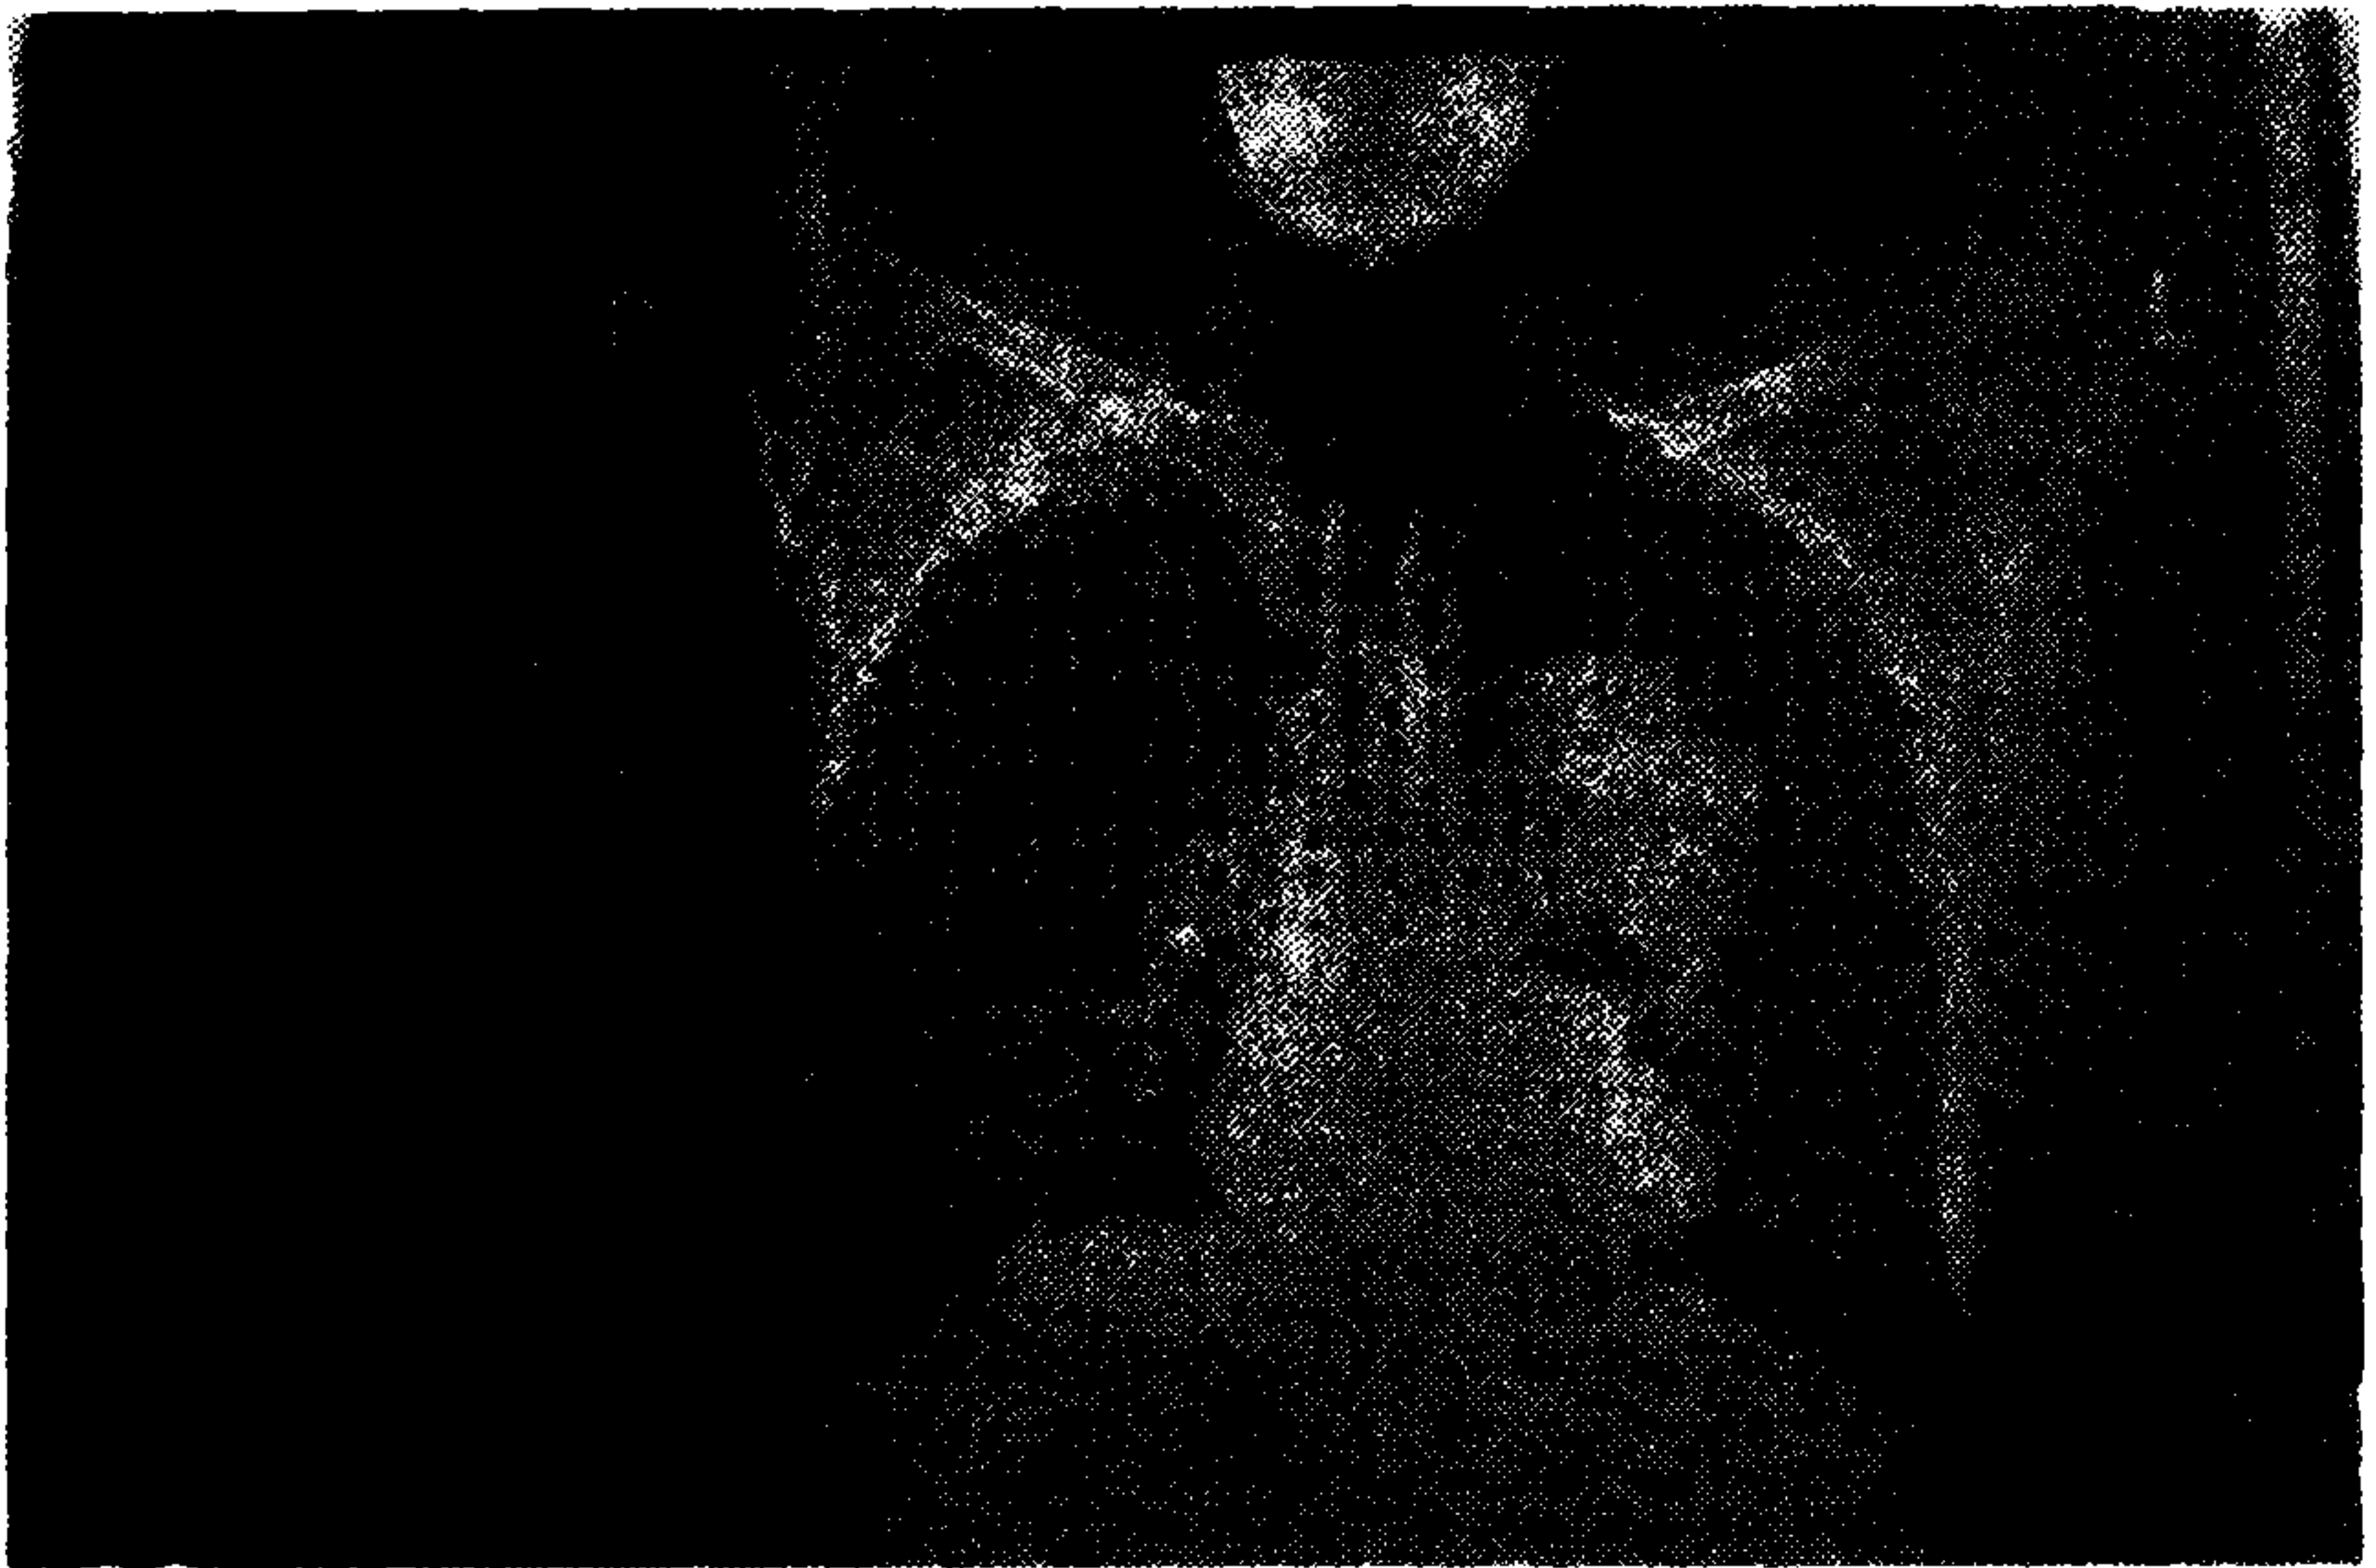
Scanogram of the second patient who has a mass, ten cm in diameter. Computed tomography shows the tumor was located left to the pulmonary artery and aorta, besides the bronchial bifurcation. It was a solid mass with several lymphadenopathies.
